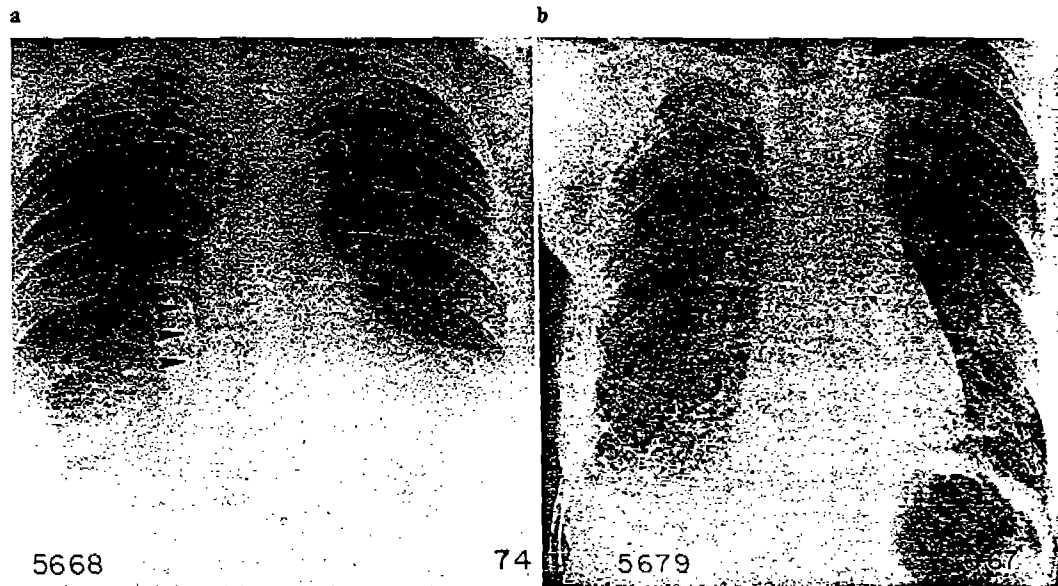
a Chest roentgenogram of case 2, a 56-year-old woman. There are diffuse linear opacities at both lung bases with blunting of the costophrenic angles as well as plaques and diffuse pleural thickening. A mediastinal calcification is indicated by arrows. b This roentgenogram is of her 58-year-old husband. There are diffuse linear
